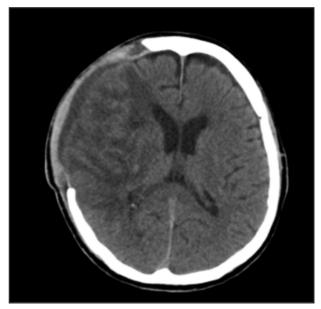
Repeated CT Brain post right parito-temporal craniotomy. Previously seen right MCA infarct with haemorrhagic transformation showed involution changes with less perilesional oedema.
